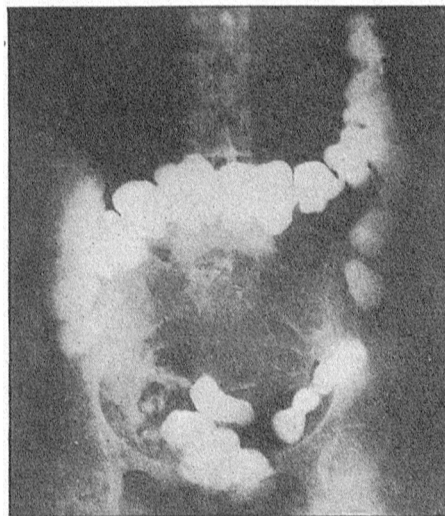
No. 6040. X-ray plate showing 96-hour stasis.
